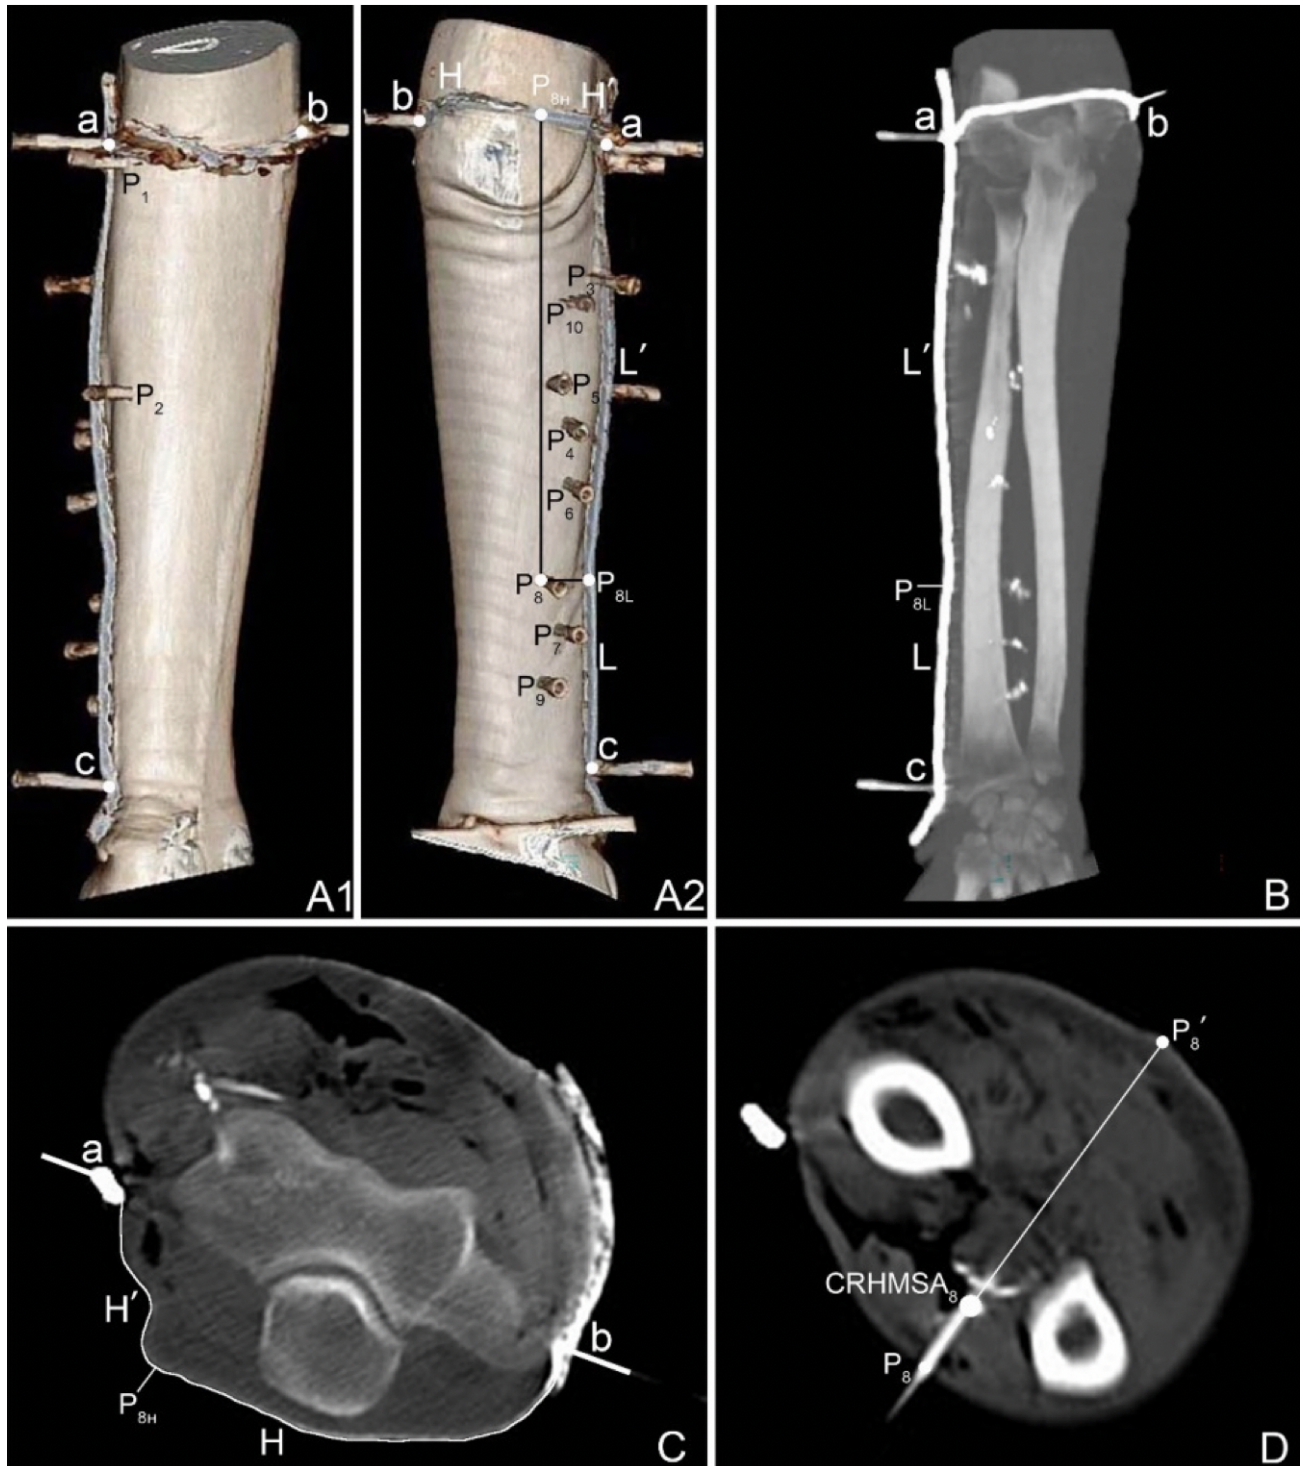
Spiral CT localisation image of the CHRMSA of the extensor pollicis brevis muscle. A: Spiral CT localization image showing the position of each CHRMSA of the anterior forearm muscles on the body surface and the designed reference line. (A1) anterior forearm, (A2) posterior forearm. a=lateral epicondyle of the humerus; b=medial epicondyle of the humerus; c=radius styloid process. P8=the body surface projection point of the CHRMSA of the extensor pollicis brevis muscle. P8H=the intersection of the vertical line through P8 and the H line. P8L=the intersection of the horizontal line through P8 and the L line. a-P8H=H', a-P8L=L'. B: Measurement of the length of the L and L' lines on the coronal section. C: Measurement of the lengths of the H and H' lines on the cross section. D: Measurement of the depth of CHRMSA8 on the cross section.
